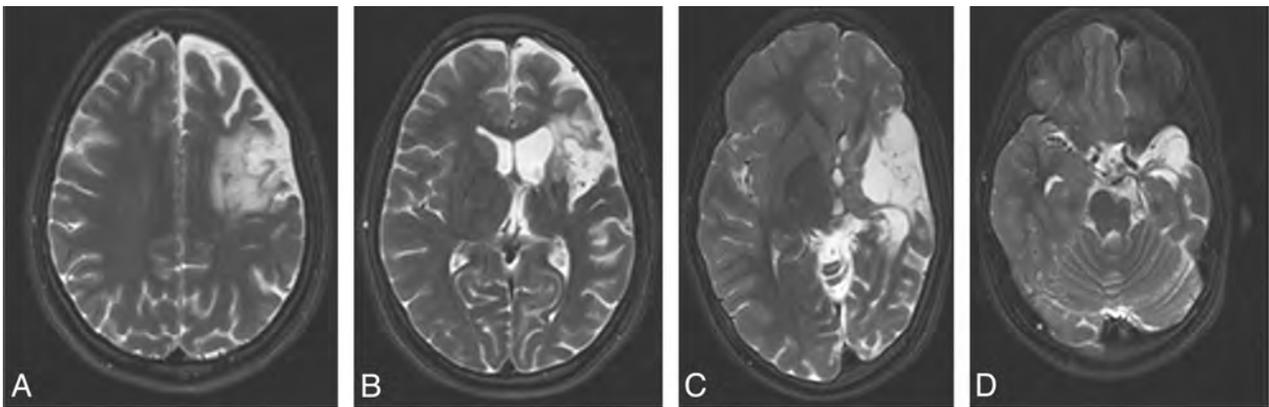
A and B, Axial T2-weighted images demonstrate high T2 signal in the frontal subcortical white matter consistent with white matter gliosis. There is thinning and high T2 signal in the frontal cortex consistent with cortical gray matter injury. C, Axial T2-weighted image at the level of the basal ganglia of a different patient demonstrates cystic changes involving both cortical and deep gray matter, with extensive involvement of the basal ganglia, thalamus, and adjacent major white matter tracts. D, Axial T2-weighted image at the level of midbrain-pons junction demonstrating significant asymmetry of cerebral peduncles, reflecting left sided Wallerian degeneration.
